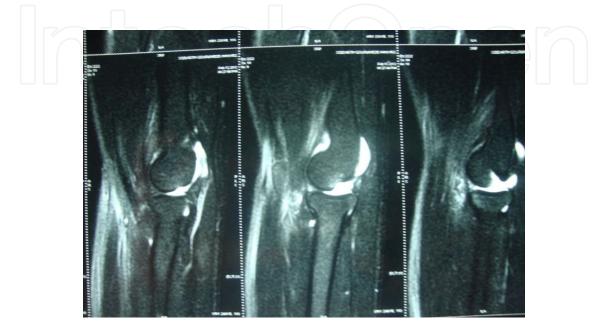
Sagital T2 MRI-showing LUCL and posterior capsular tear
